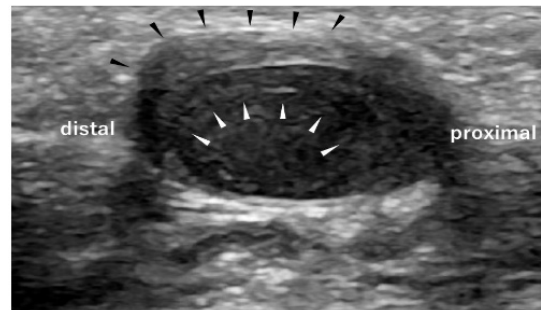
Ultrasonography. Ultrasonography showing a pulsatile aneurysm with a maximum diameter of 16.0 mm and a two-layered mural material that could be thrombus. The outer material (black arrow heads) was high-echoic, while the inner material (white arrow heads) was low-echoic.
